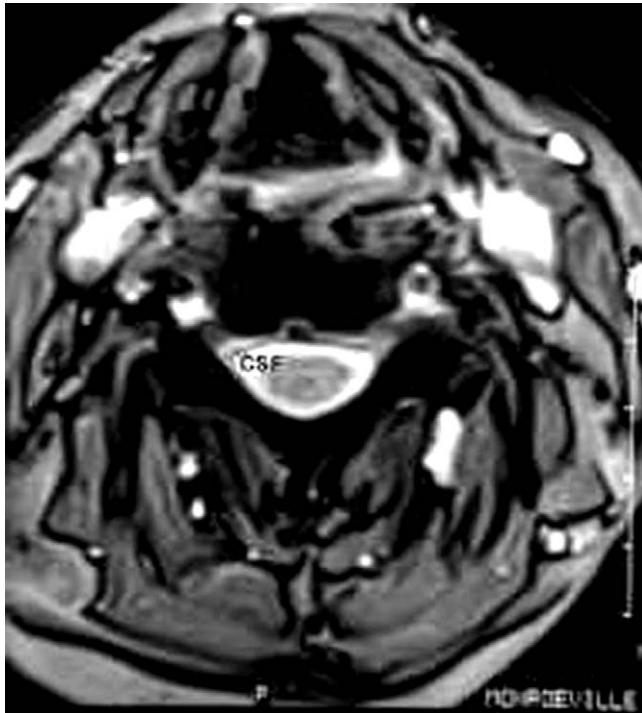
Axial T2-weighted MRI image at a relatively normal level. Note the bright white cerebrospinal fluid ring (CSF) surrounding the cord.
